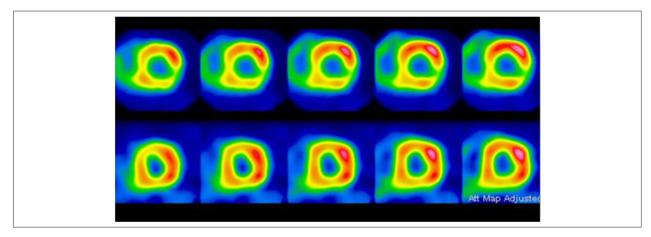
First line = study with ¹⁸F-FDG demonstrating heterogeneous uptake of the radiotracer with greater intensity in the anterior and anterolateral walls, suggesting an inflammatory process in these regions. No uptake of radiotracer in the inferolateral wall and lower intensity in the inferior and inferoseptal walls. Second line = study with ⁹⁹mTc-sestamibi demonstrating preserved myocardial perfusion, including the inferolateral wall with no areas of myocardial fibrosis.
